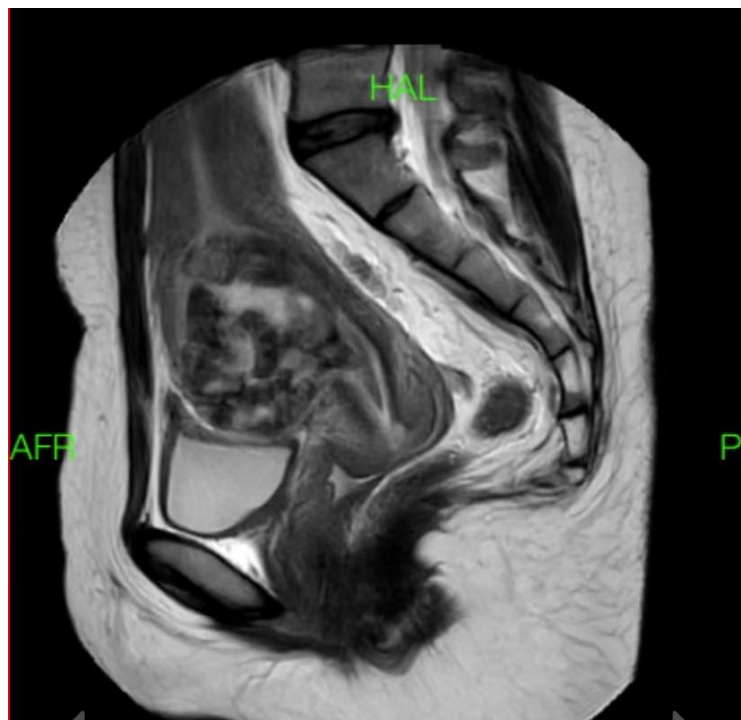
Pelvic MRI image
